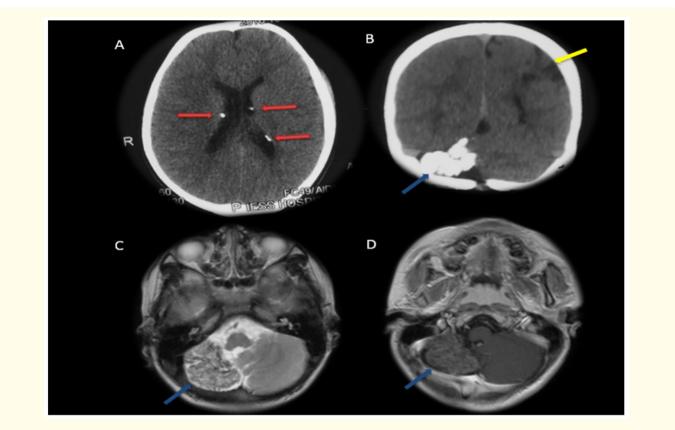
CT scan (A) axial (B) coronal. MRI (C)T2 sequence and T1 (D) sequence Calcified subependymal nodules inside lateral ventricles (red arrows), cortical tuber with white matter radial migration line in left hemisphere (yellow arrows) Calcified tuber with contrast in right hemisphere (blue arrows). Right hemisphere is atrophied by lesion.
